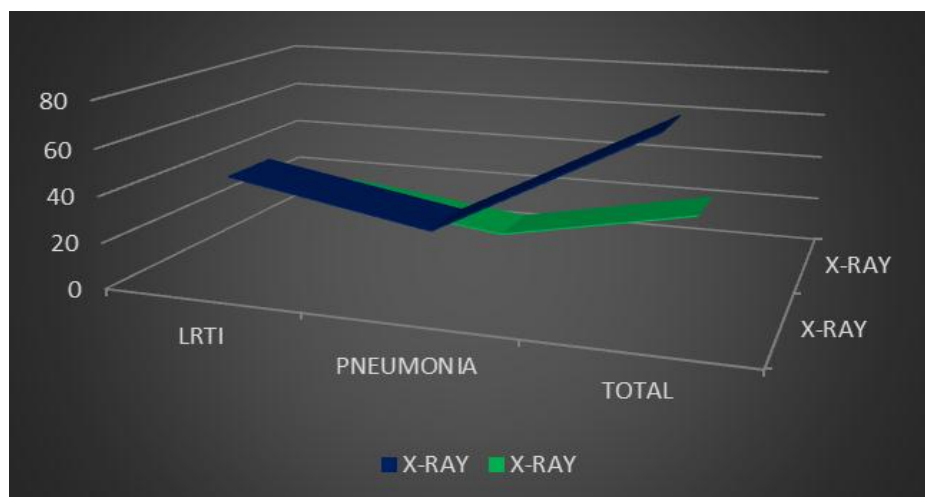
X-Ray Performed In Patients With Lrti And Pneumonia.
